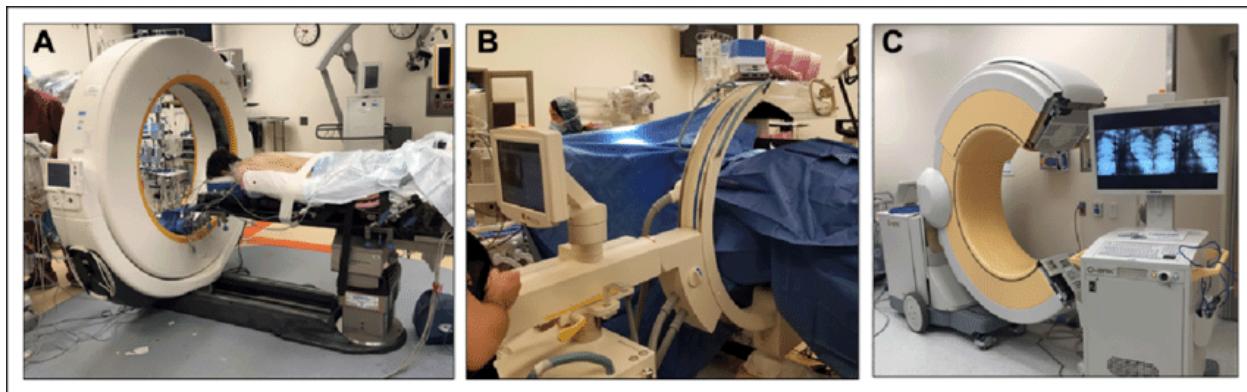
Intraoperative computed tomography (CT) - based 3-dimensional navigation technology systems: (A) fan beam CT, (B,C) cone beam CT. Hussain, I., Cosar, M., Kirnaz, S., Schmidt, F.A., Wipplinger, C., Wong, T. and Härtl, R., 2020. Evolving navigation, robotics, and augmented reality in minimally invasive spine surgery.
